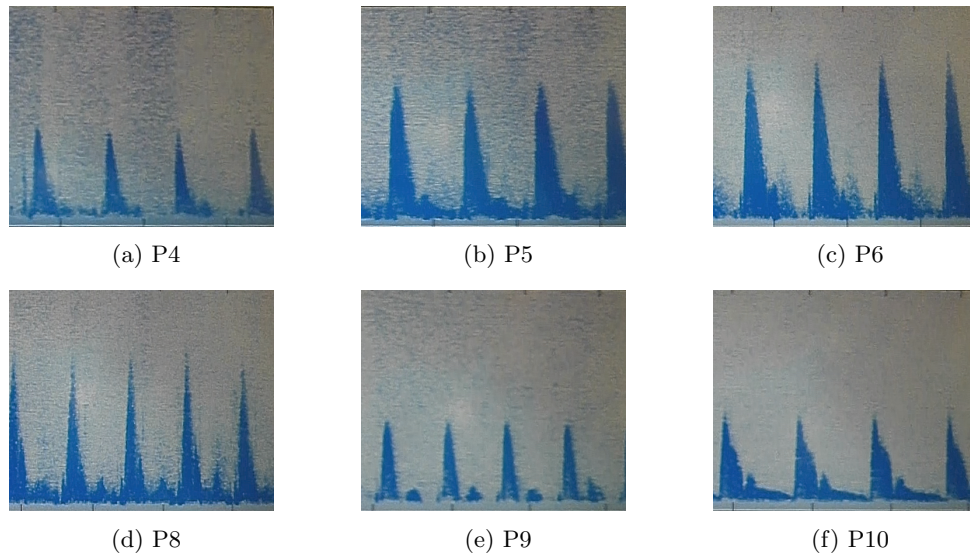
Interpatient variability captured by USCOM display at IPP, collected by an expert sonographer across different participants, where ‘P’ followed by a number indicates an individual participant.
